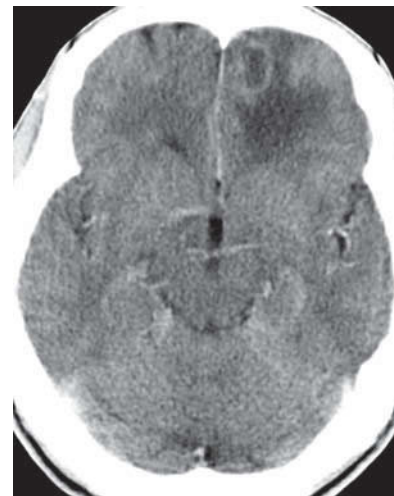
Cerebral toxoplasmosis. Head CT post-contrast enhancement demonstrates ring-enhancing lesion of left frontal lobe with vasogenic edema. Courtesy: Mahesh Jayaraman, MD.
